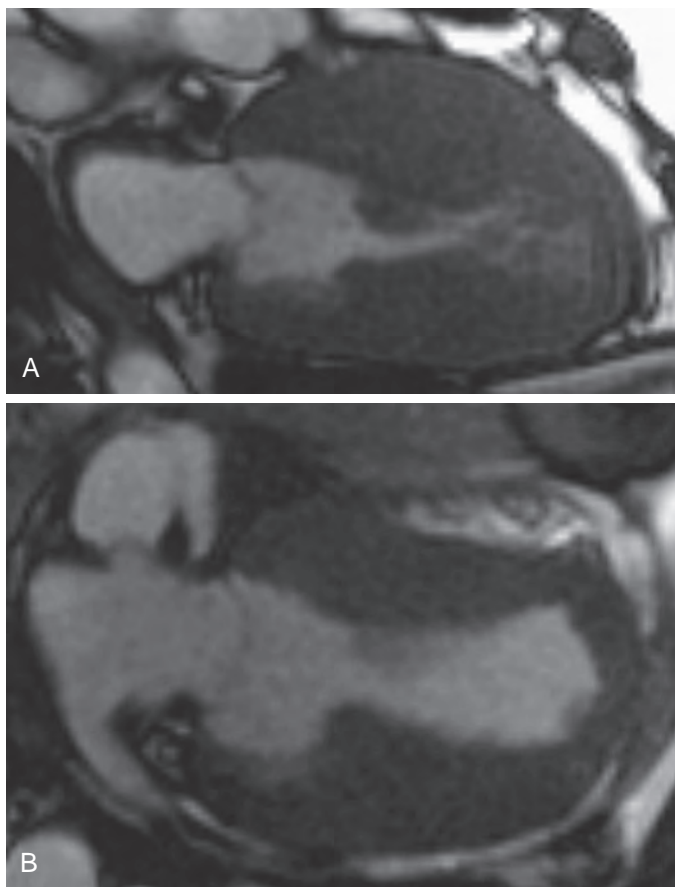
Cardiac magnetic resonance images of a patient with apical variant hypertrophic cardiomyopathy and shown during diastole. (A) Obliteration of the apical cavity is demonstrated before surgical resection. (B) Image depicts the surgical creation of a significantly enlarged left ventricular cavity after resection. (Reproduced with permission from Schaff HV, Brown ML, Dearani JA, et al. Apical myectomy: a new surgical technique for management of severely symptomatic patients with apical hypertrophic cardiomyopathy. *J Thorac Cardiovasc Surg.* 2010;139:635.)
